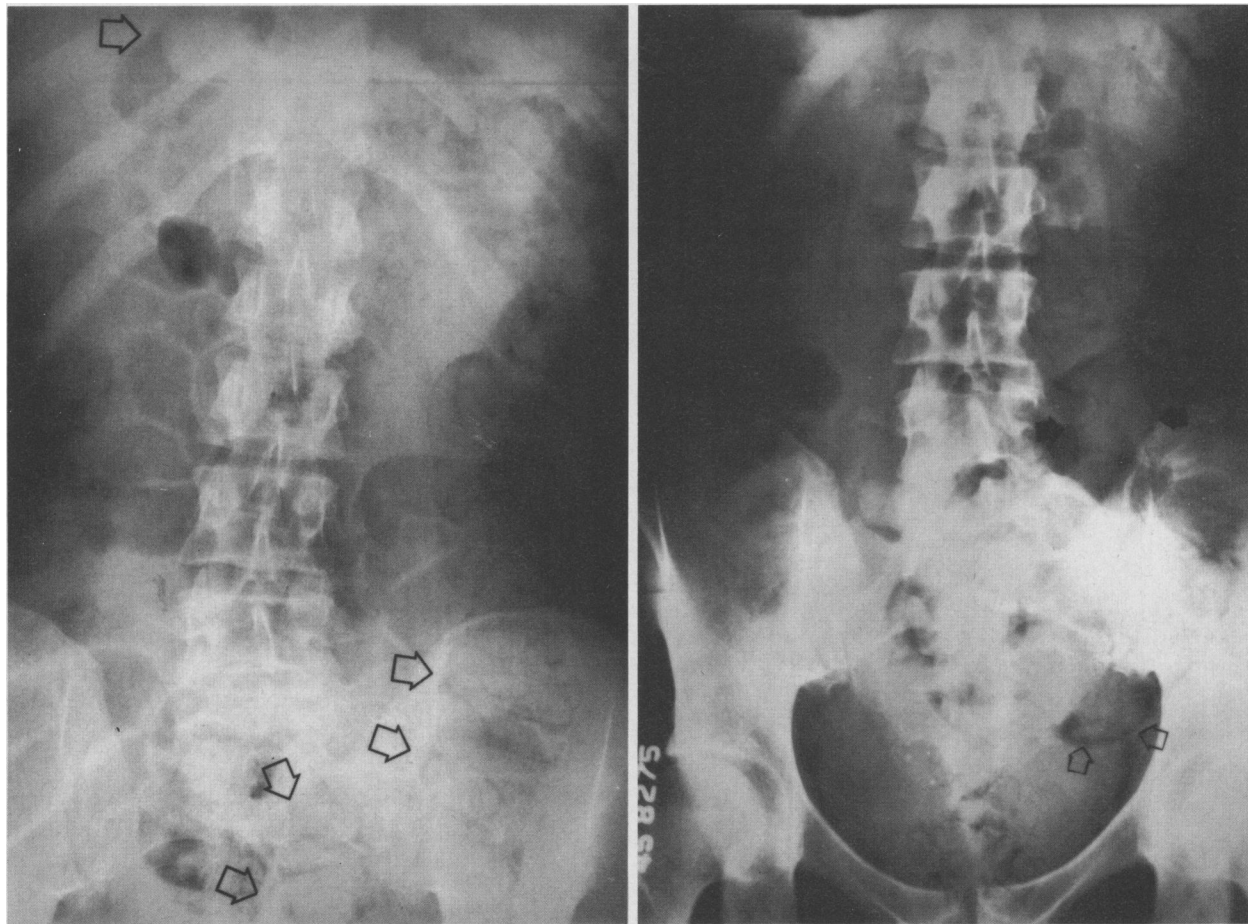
Plain abdominal roentgenogram (left) reveals multiple diffuse, rounded radiodensities in the region of the rectosigmoid and the stomach (arrows). A later radiograph (right) of the same patient demonstrates fluid-filled condoms at the left iliac crest and in the rectosigmoid (arrows)
